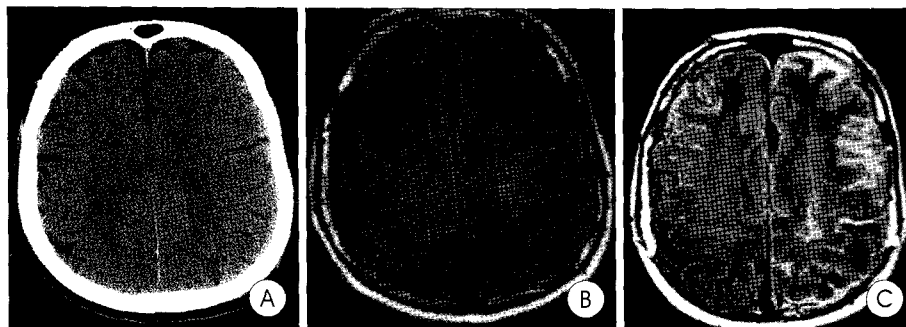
A : Computed tomography scan obtained immediately following clinical deterioration shows normal finding except lacunar infarcts. B : Immediate post-rescue magnetic resonance image scan also shows no definite evidence of stroke. C : Repeated magnetic resonance image scan, 1 day following thrombolytic therapy. Axial T2 weighted fluid attenuation inversion recovery image shows high signal intensity filled with the entire sulcal spaces of the left hemisphere.
